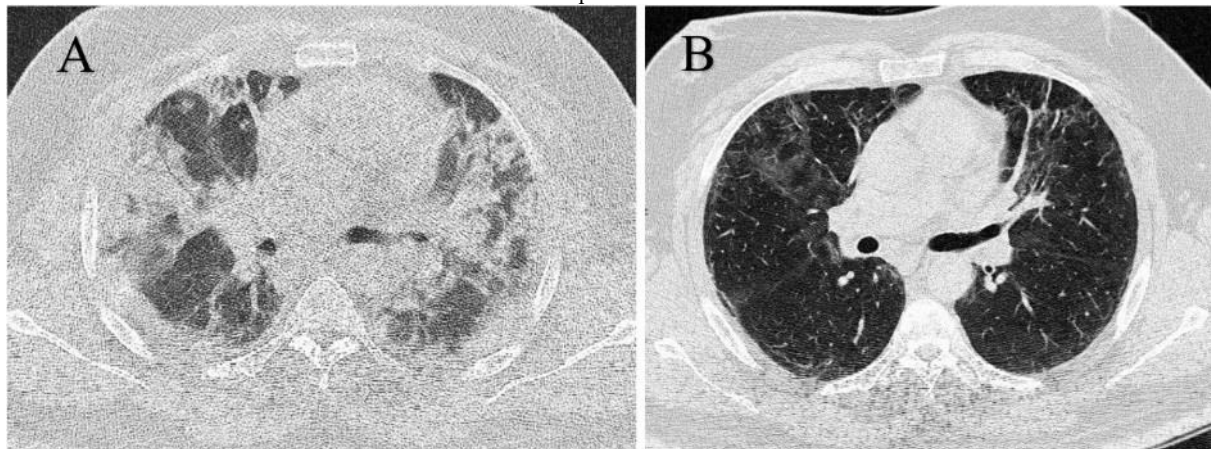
A: Initial chest CT scan of another ICU admitted patient who was 75 years old, which shows peripheral ground glass opacities and consolidations in both lower lobes. (The TLI score was 18.) B: Follow-up CT of the same patient shows ground glass opacities and fibrotic bands.
